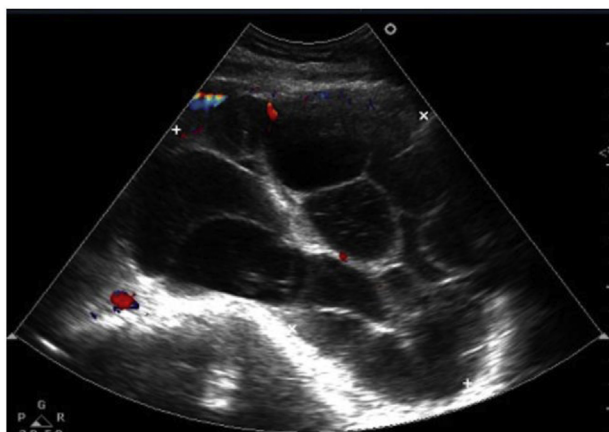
Transabdominal ultrasound: a multiseptum pelvic cyst (15.9 × 10.3 × 11.1 cm).
